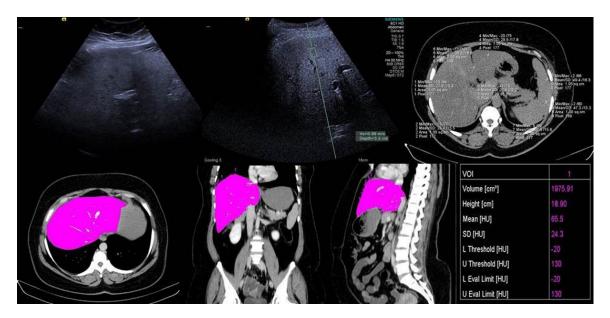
US, SWE, non-contrast CT images, and contrast CT MPR images. A 33-year old female patient, existing with grade 2 hepatosteatosis; LAI-21, the mean value of SWV 0.90 m/s, the liver volume 1975.91 cm³, the liver size 18.9 cm.
